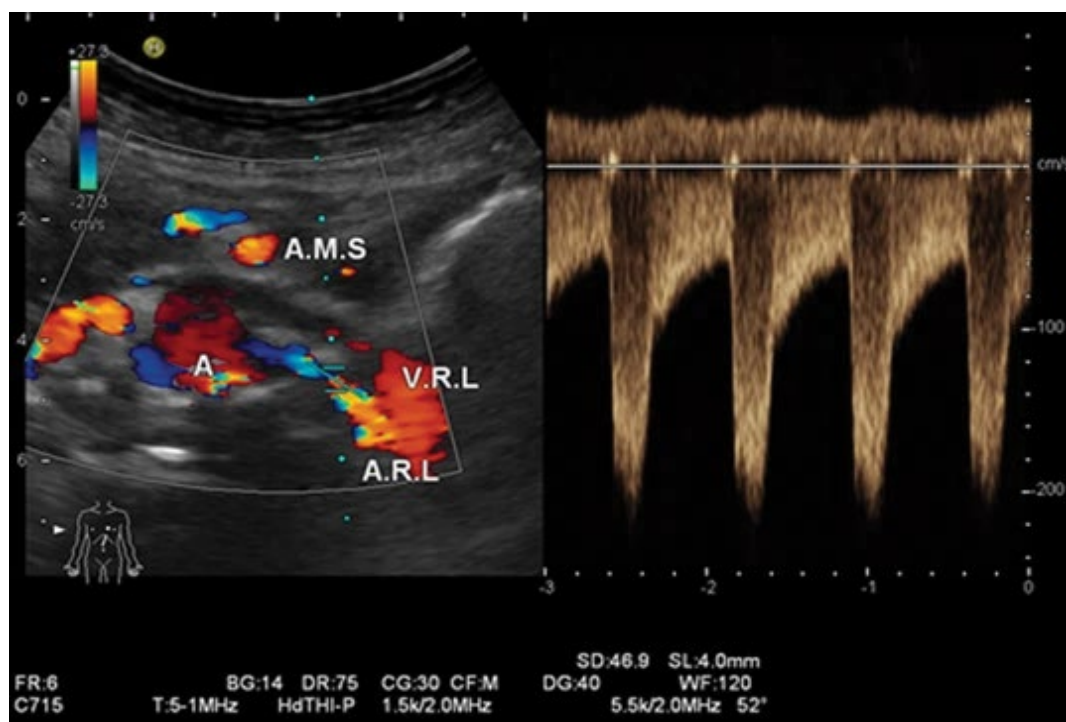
Spectral Doppler was used to complement the findings of colour Doppler in this FMD renal artery case. A peak systolic velocity (PSV) of 220 cm/s was recorded at the site of the stenosis, and a peak systolic velocity of 80 cm/s was recorded at the pre-stenotic segment of the renal artery [13]. At the stenosis, the PSV increased by a factor of 2.7 [13]. This indicates that there is greater than 50% concentric stenosis in the vasculature [13]. Spectral broadening in the ultrasound waveform and aliasing seen on colour Doppler indicate turbulence with a wide range of blood flow velocities being represented.
